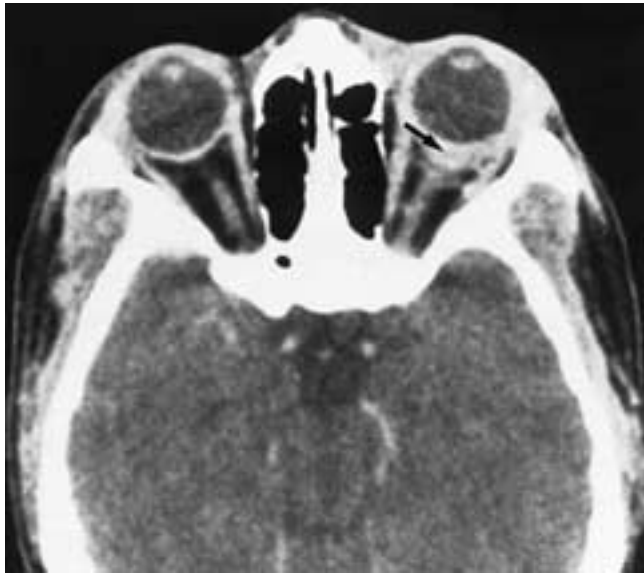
Pseudotumor. Axial CT scan shows fluid (*arrow*) and inflammatory infiltration in Tenon's space.
